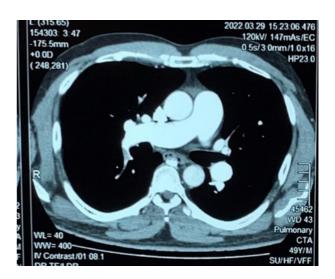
Computed tomography pulmonary angiogram with arrow pointing to pulmonary embolus
